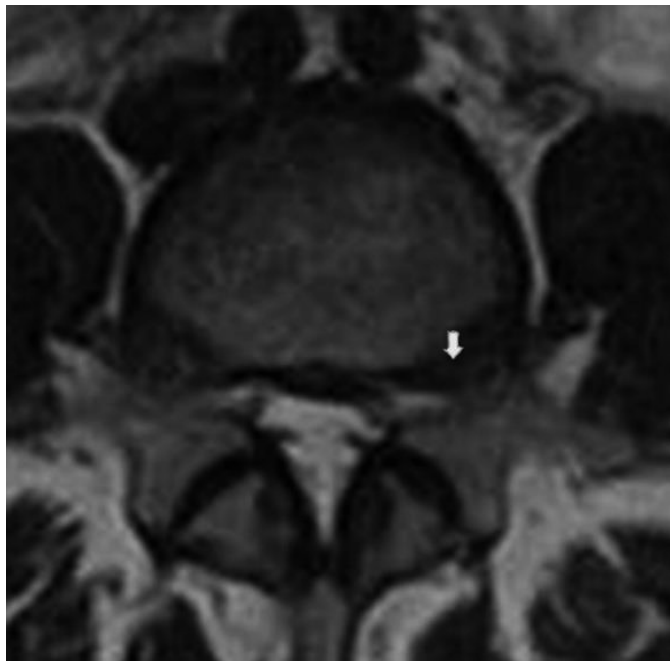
MRI visualization of the L4-L5 left-side paramedial-foraminal protrusion (arrow).
